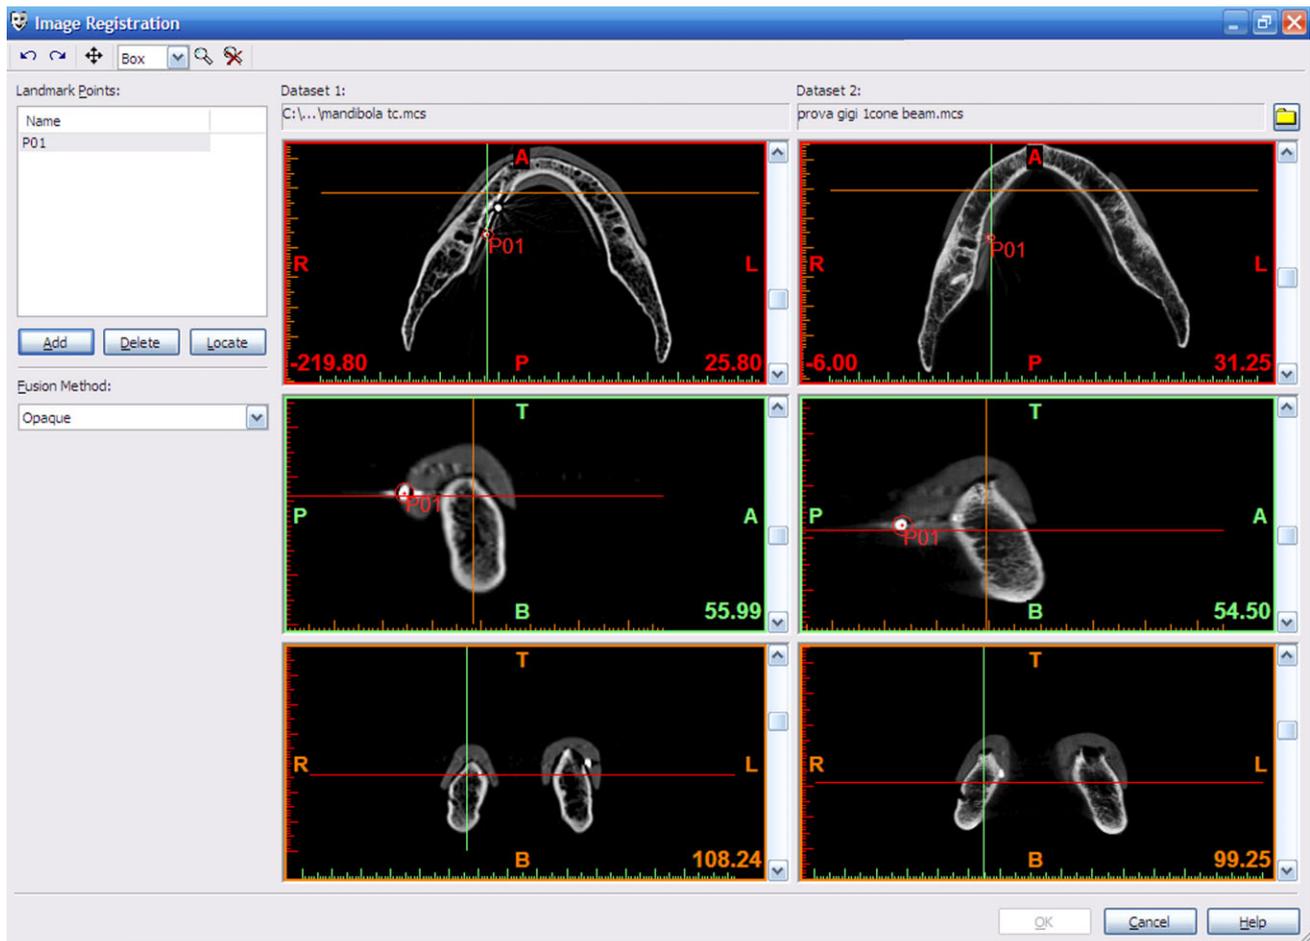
Overlapping of two data sets (cone beam computed tomography and computed tomography) of Digital Imaging and Communications in Medicine images, using the Mimics® software “image registration” tool.
